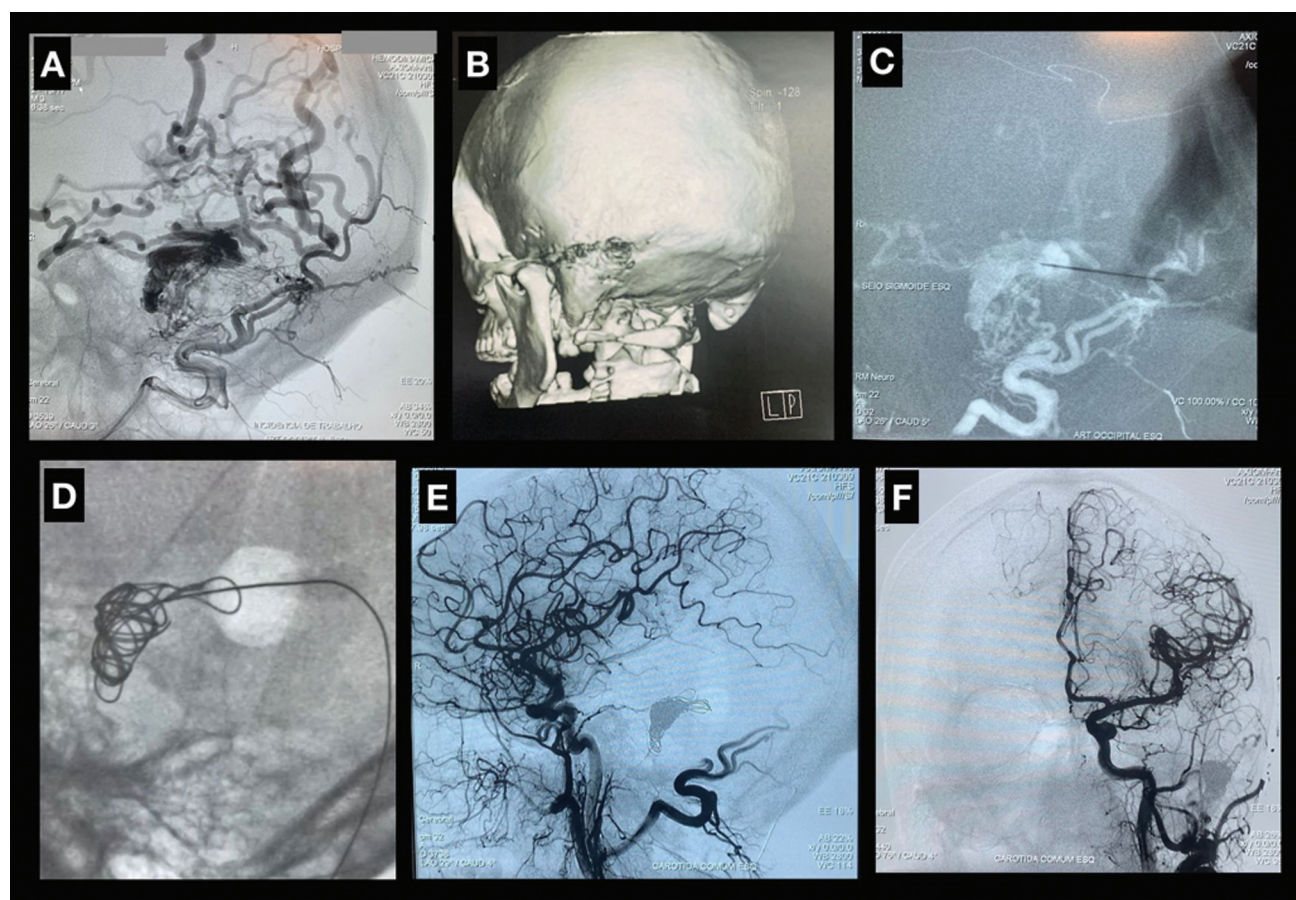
Angiogram in lateral view (A) showing the transverse-sigmoid junction was cloistered by distal transverse and proximal sigmoid sinus occlusion, leading to a prominent retrograde drainage into infratentorial engorged veins. With DSA pinpointing, a small guided craniectomy was performed on transverse-sigmoid junction, showed in 3D brain CT scan reconstruction (B). Transcranial direct puncture of the transverse-sigmoid junction under high-quality road-mapping guidance was performed (C) and was packed the the transverse-sigmoid junction with coils (D). The final angiography showed complete obliteration of the lesion (E and F).
